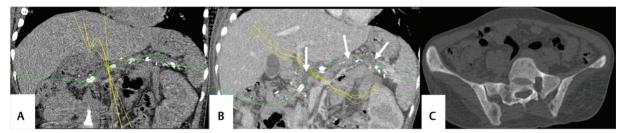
(A) Plain CT abdomen, curved MPR image shows multiple pancreatic parenchymal and ductal calcifications (arrows). (B) Contrastenhanced CT abdomen, curved MPR image shows ductal dilatation and ductal calcifications. (C) Plain CT pelvis, axial section, bone window shows multiple lytic lesions involving bilateral iliac bones suggestive of brown tumor.
